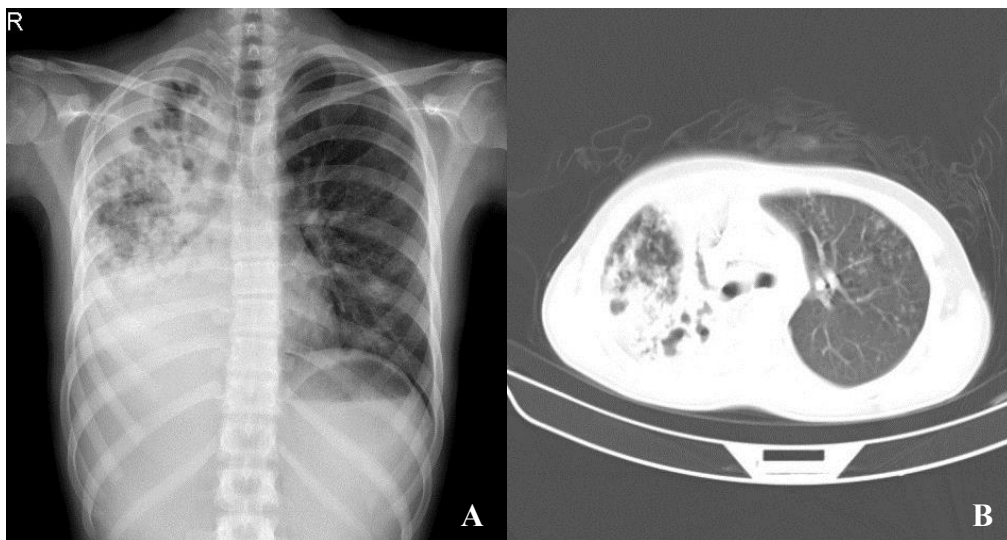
(A) Chest X-Ray, and (B) CT- Scan of the patient
